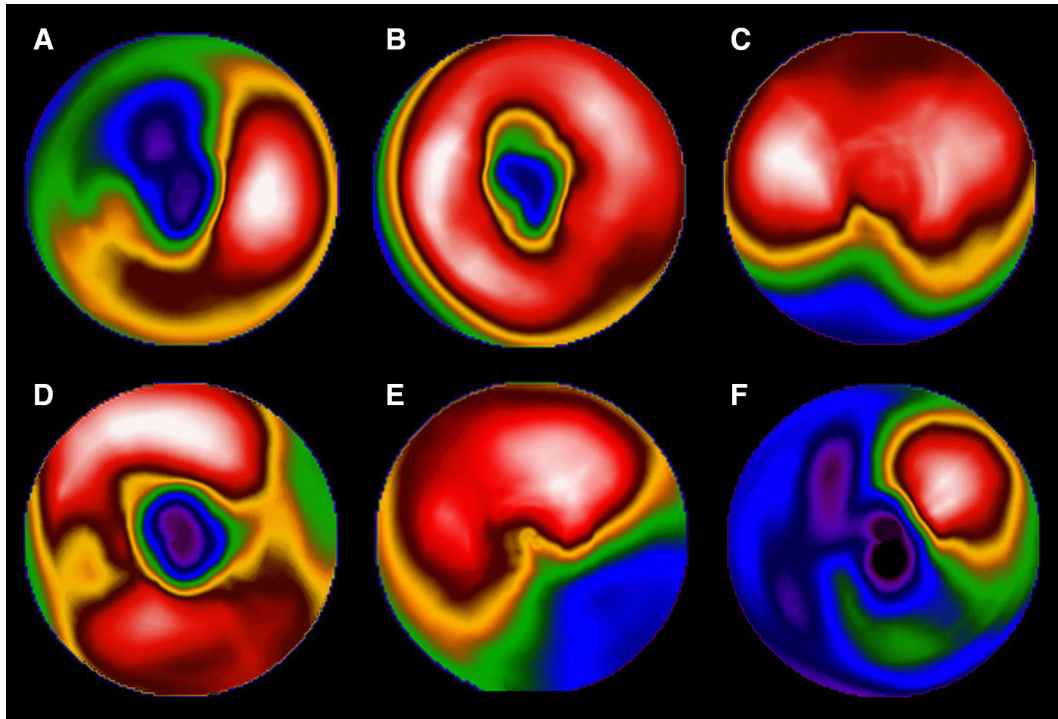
Prototypical cases of vessel-related ischemia (VRI) at myocardial perfusion scintigraphy: single-VRI involving left anterior descending (LAD) [proximal (A) vs non-proximal (B)], single-VRI not involving LAD (C), two-vessel-VRI involving LAD (D), two-vessel-VRI not involving LAD (E), and three-vessel-VRI (F).
